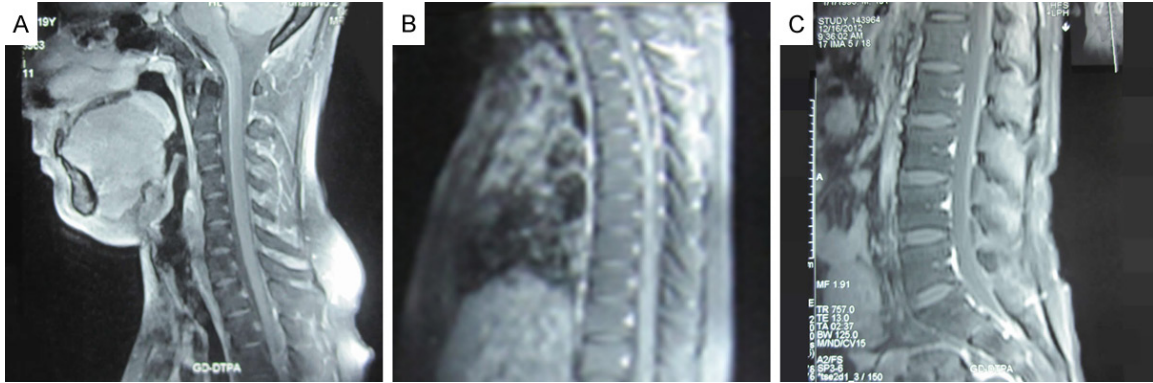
Spinal cord MRI findings. Sagittal T1WI images of the neck (A), chest (B) and abdomen (C) showing no distant metastasis to the spinal cord after contrast medium injection.
